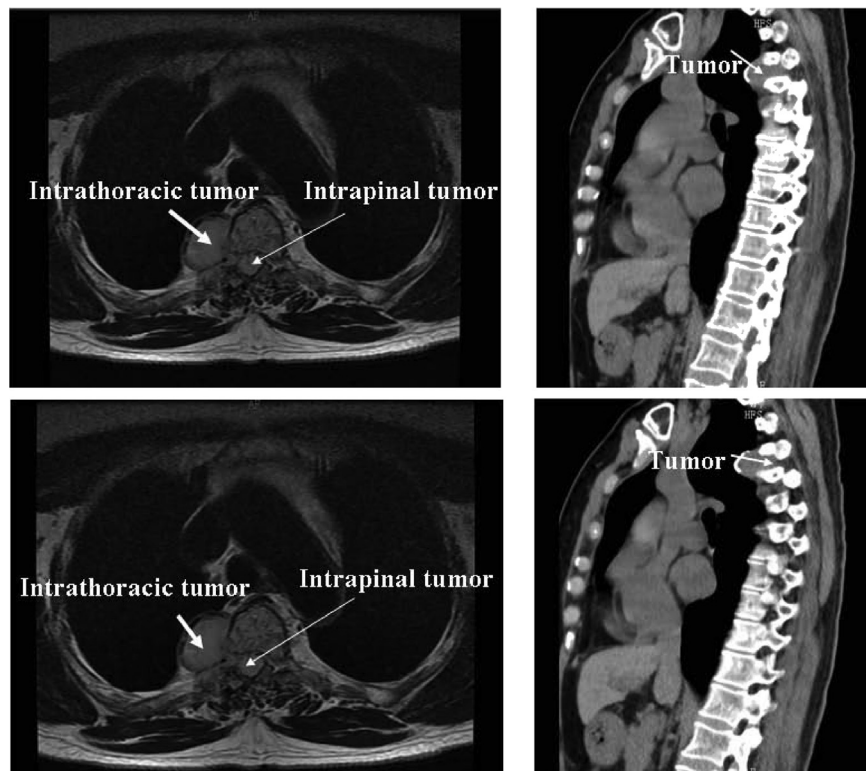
Magnetic resonance image showing a posterior mediastinal dumbbell tumor.
